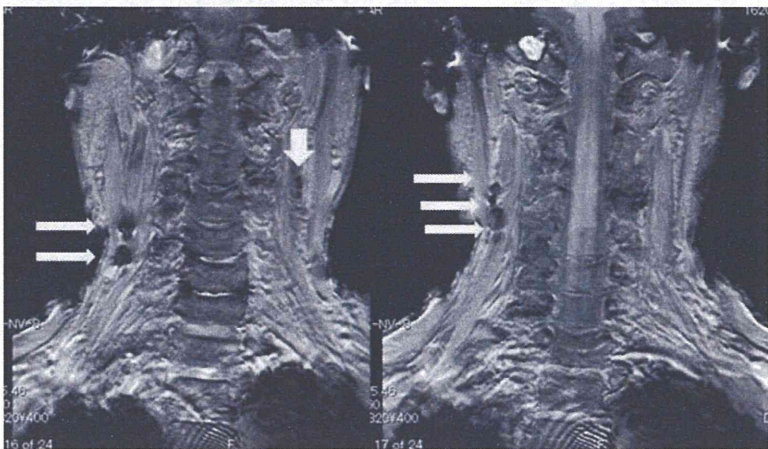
Arrows show lymph nodes detected with low signal intensity on fast-field echo (FFE) T1-weighted images at 24 h after injection into the affected (right) and the unaffected side. FFE T1-weighted image after 24 h showed the clearest images of the lymph nodes, but visualized larger numbers of additional lymph nodes, probably on and after the second echelon.
